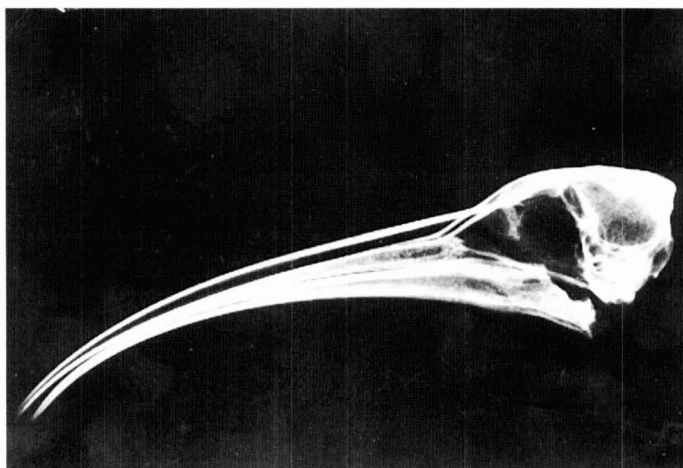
Lateral radiography of a dry cranium of the *Geronticus eremita*.
